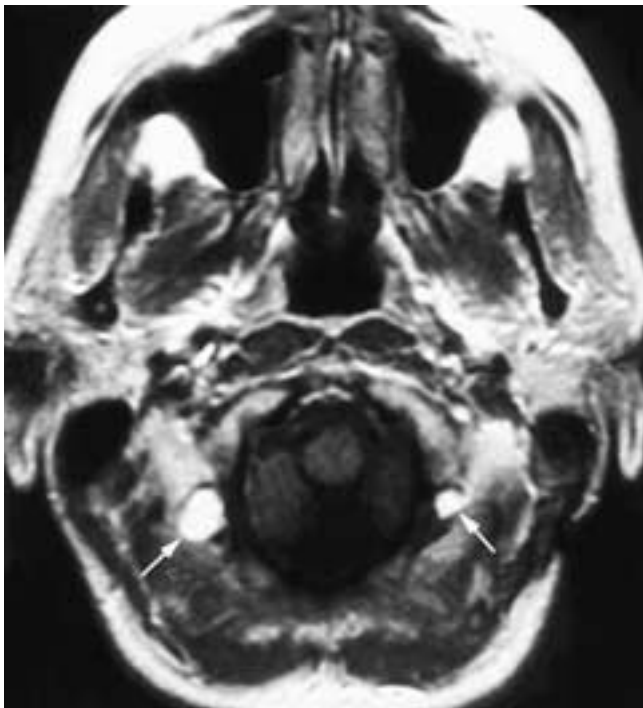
Axial T1-weighted image through the level of the foramen magnum shows a condylar vein with high signal intensity on each side of the neck (*arrows*). Asymmetry of the condylar veins is normal, and the high signal intensity reflects slow or turbulent venous flow. The importance of the condylar veins lies in their not being mistaken for abnormal lymph nodes.
